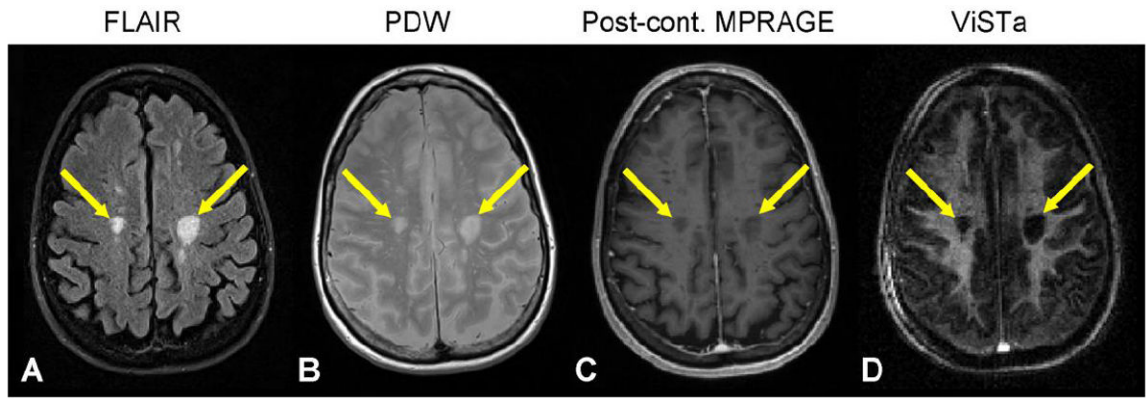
FLAIR (A), PDW (B), post-contrast MPRAGE (C), and single-echo ViSTa (D) images from an MS patient. Chronic lesions (arrows) show significant signal reduction in the ViSTa image.
